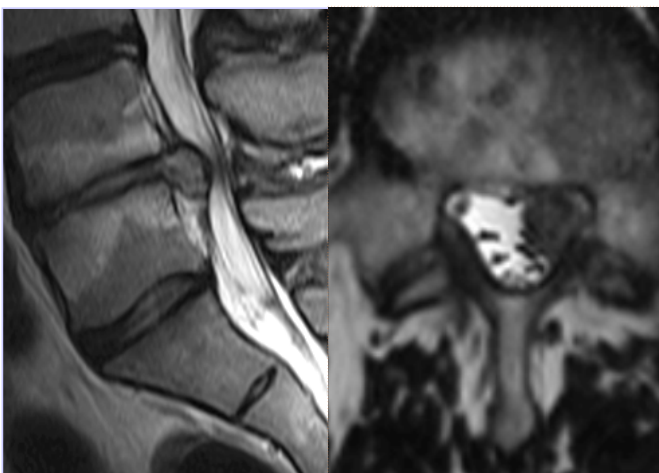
MRI showing a herniated lumbar disc in the L4-L5 disc space compressing the left nerve root. Reproduced with permission from Øystein Nygaard
